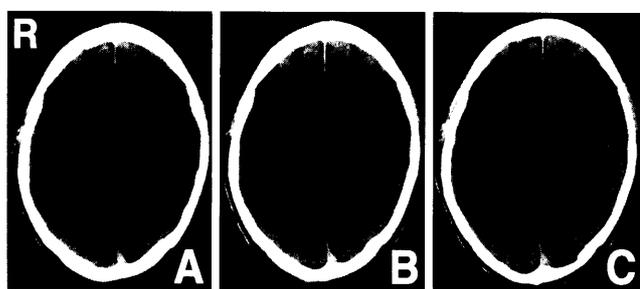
Computed tomography scans showing sequential changes in a 76-year-old man with chronic subdural hematoma manifesting as mild headache. (A) Chronic subdural hematoma appeared as near-low density in the left cerebral hemisphere on the day of diagnosis. (B) Etizolam (3.0 mg orally per day) was given for 14 days. (C) The volume of hematoma decreased gradually and disappeared after almost 3 months.
